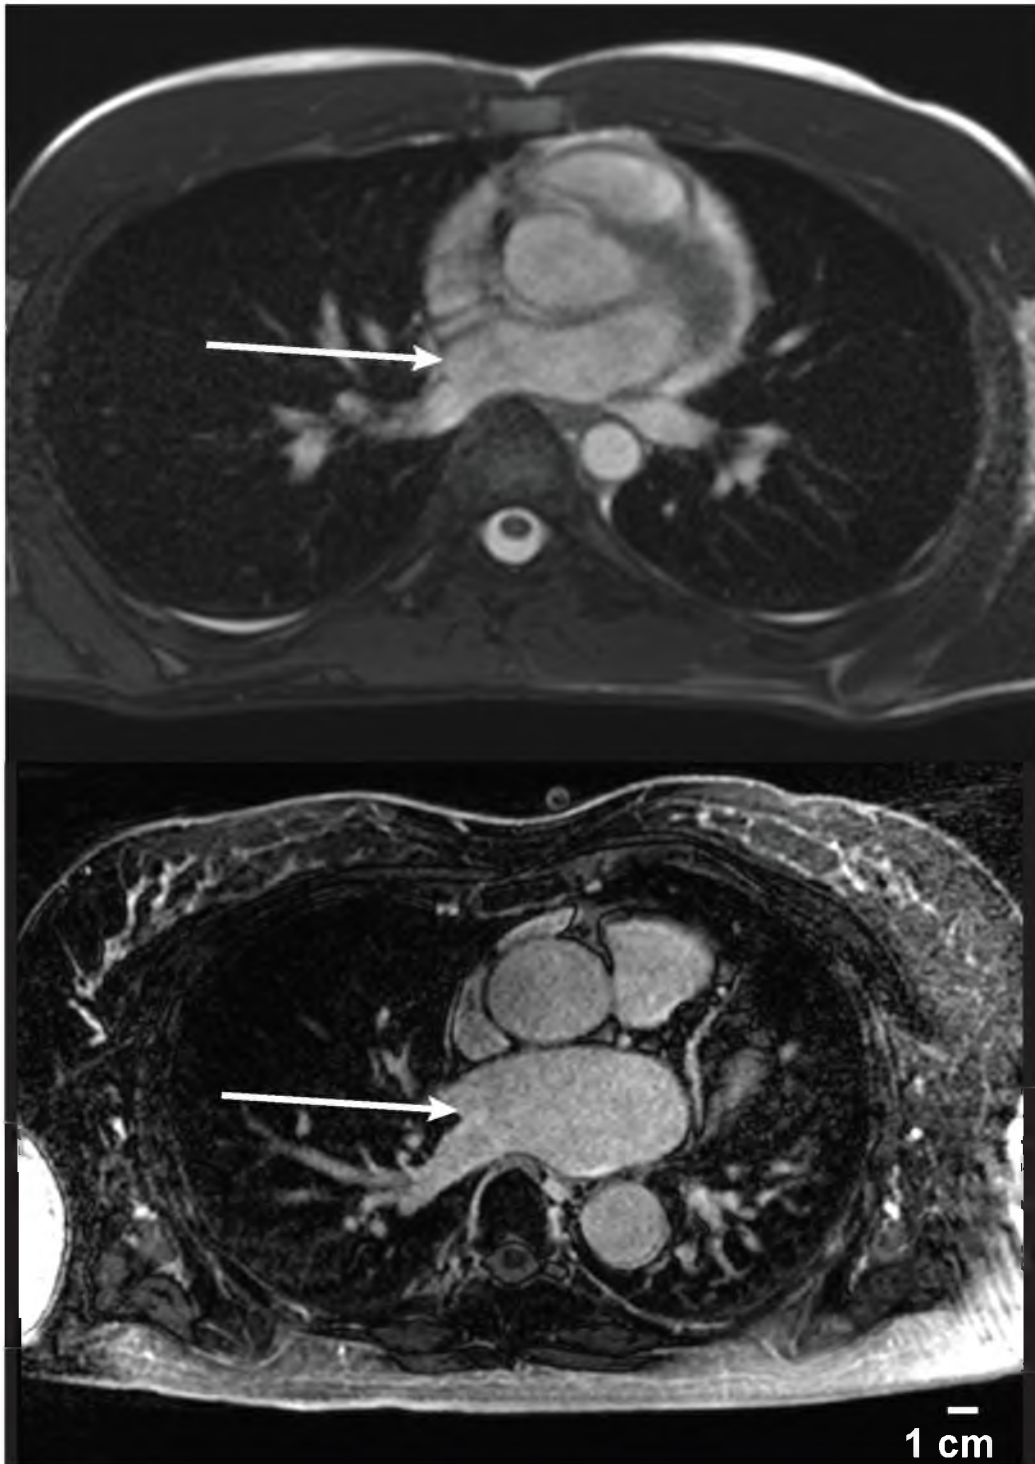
MRI of structurally normal and dilated left atria (LA). The top image depicts my, I hope, structurally normal LA. The bottom image shows an approximately slice matched dilated LA of a patient with AF. The AF patient's LA is nearly 40 mL larger in volume than my own, in spite of my being 0.22 m taller and 18 kg heavier.
